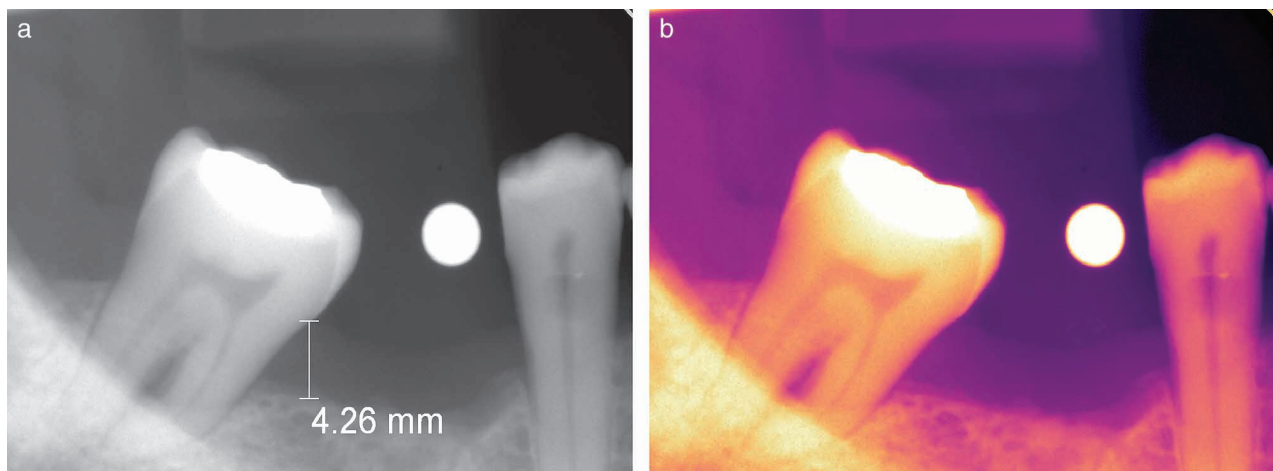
Example of black-and-white (a) and color-coded (b) digital radiographs. A measurement value is indicated in (a).
